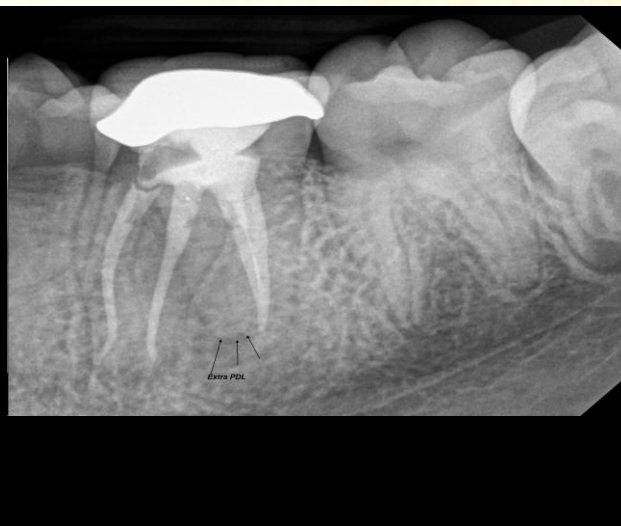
Pre-op X-ray (Angulated view)
